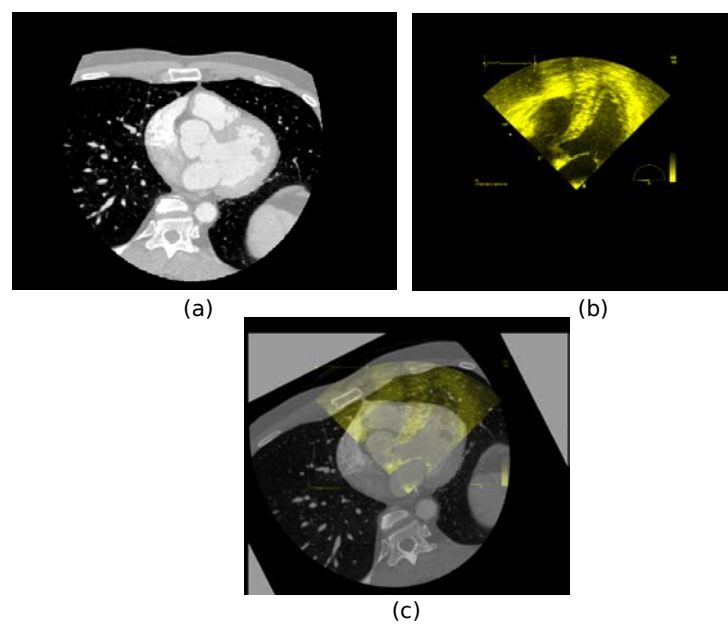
a) US Image 3. b) Resampled CT image. c) Result of the our proposed registration.
